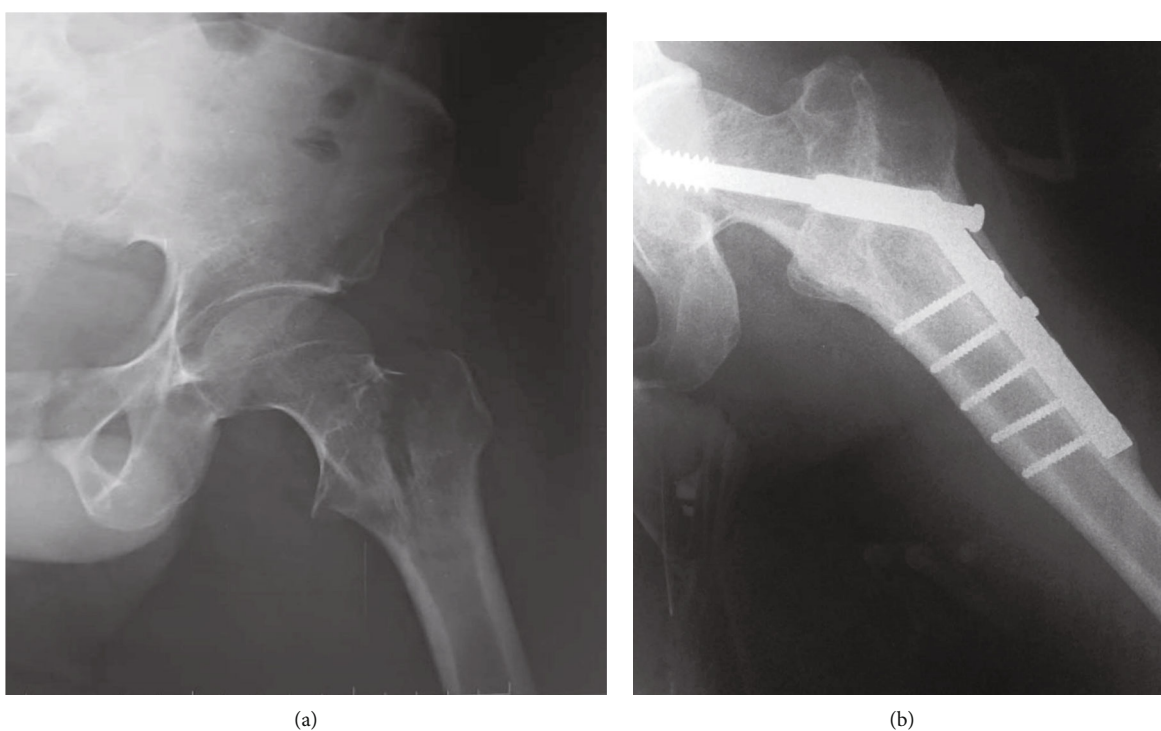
X-rays of patient 5. (a) Pertrochanteric fracture of the left hip class 31A1.2 according to AO/OTA. (b) Osteosynthesis by DHS.
